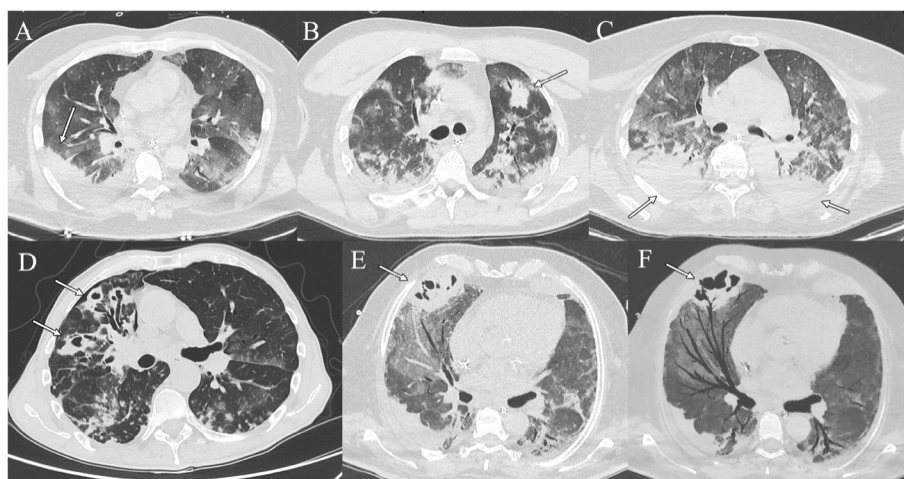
Axial HRCT images of ICU patients infected with SARS-CoV-2 virus demonstrating the appearance of extensive consolidations associated with worsening of COVID-19 pneumonia (arrows in A, B and C). Superimposed secondary bacterial infections sustained by *Acinetobacter* (A), *Pseudomonas Aeruginosa* (B) and *Klebsiella pneumoniae* (C) were later confirmed. A different COVID-19 patient admitted to ICU showing lung consolidations complicated by small cavitations in the medium and right inferior lobes (arrows in D and E) caused by a superinfection by *Aspergillus fumigatus*; minimum Intensity Projection reconstruction demonstrating a direct communication between the cavitation and the bronchial tree (arrow in E); superinfection of was detected
